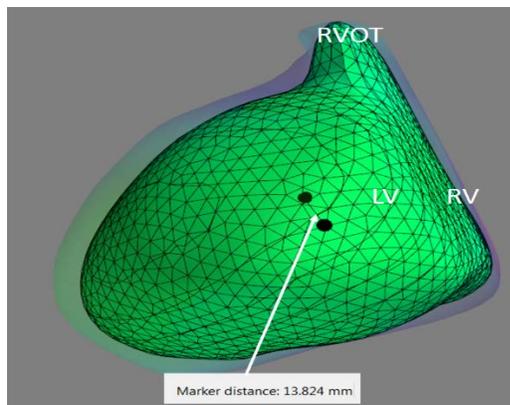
Epicardial merged model with Python. Black dot – center marker of late activation zone on CT and MRI model. Marker distance = 13.8 mm.
